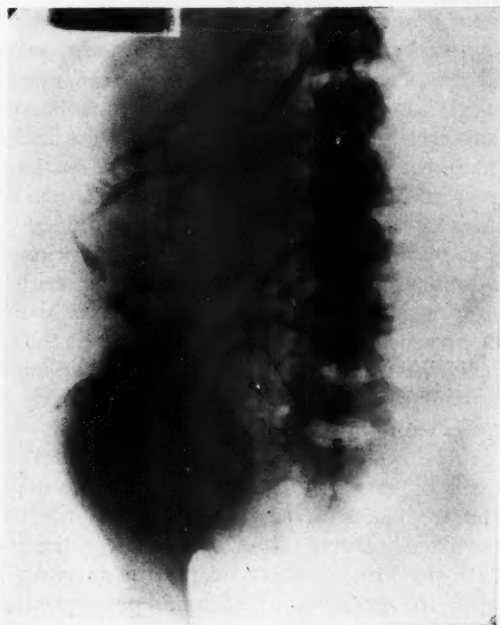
Anteroposterior roentgenogram showing transverse presentation of the fetus high above the pelvic brim with no uterine shadow.
